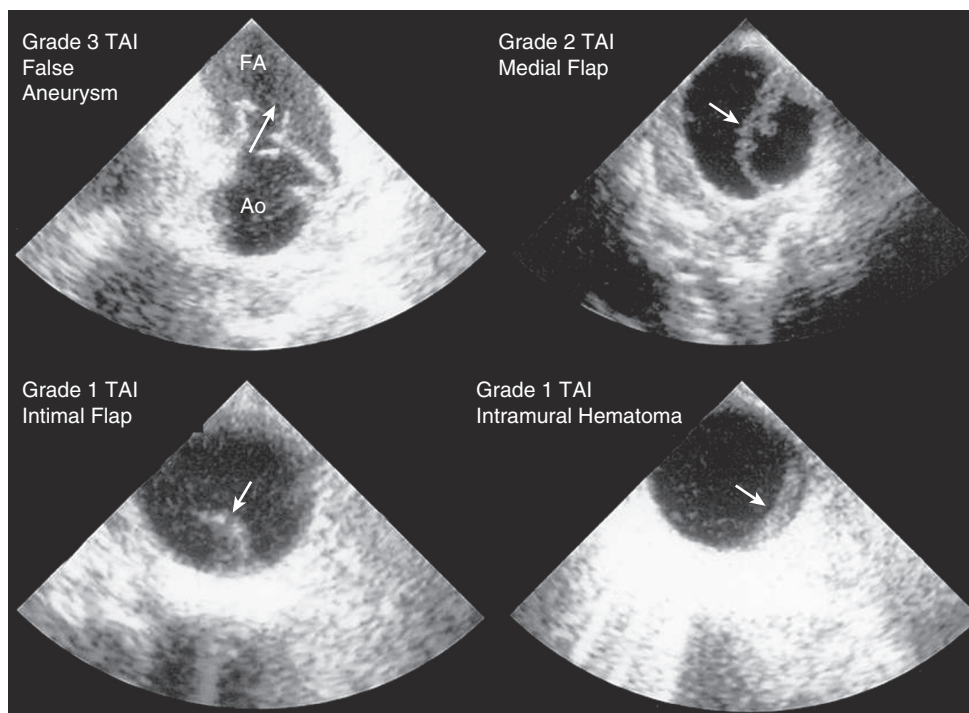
■ TEE images of grades 1, 2, and 3 traumatic thoracic aortic injury (TAI). Ao, aorta; FA, false aneurysm. (From Goarin J-P, Cluzel P, Gosgnach M, et al.: Evaluation of transesophageal echocardiography for diagnosis of traumatic aortic injury. *Anesthesiology* 93:1373, 2000.)
